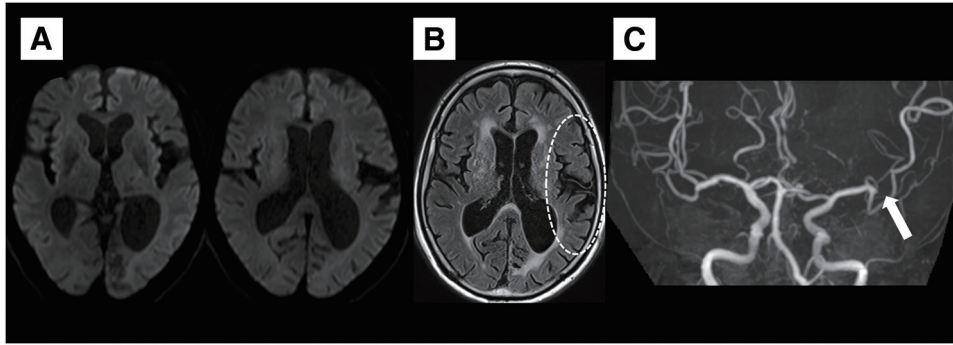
Baseline MRI. (A) Diffusion-weighted MRI showed no high-signal intensity areas. (B) FLAIR imaging revealed HVS in the left MCA territory (white dotted circle). (C) MRA showed occlusion of the left MCA M2 segment (white arrow). HVS, hyperintense vessel sign; MCA, middle cerebral artery
